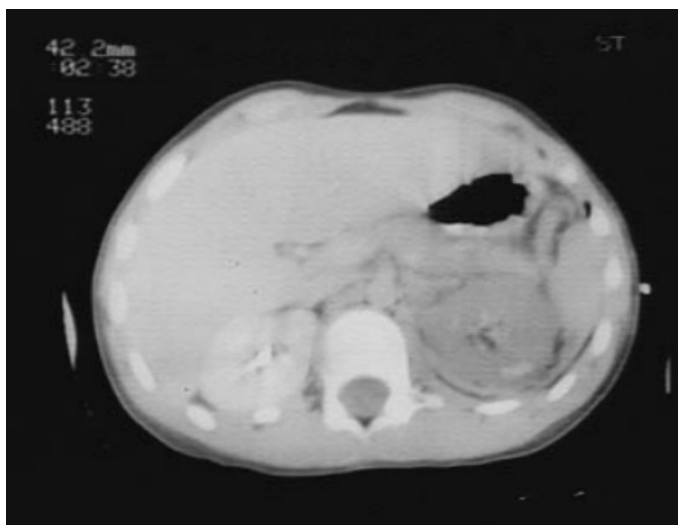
CT appearance of left Class V renal injury
